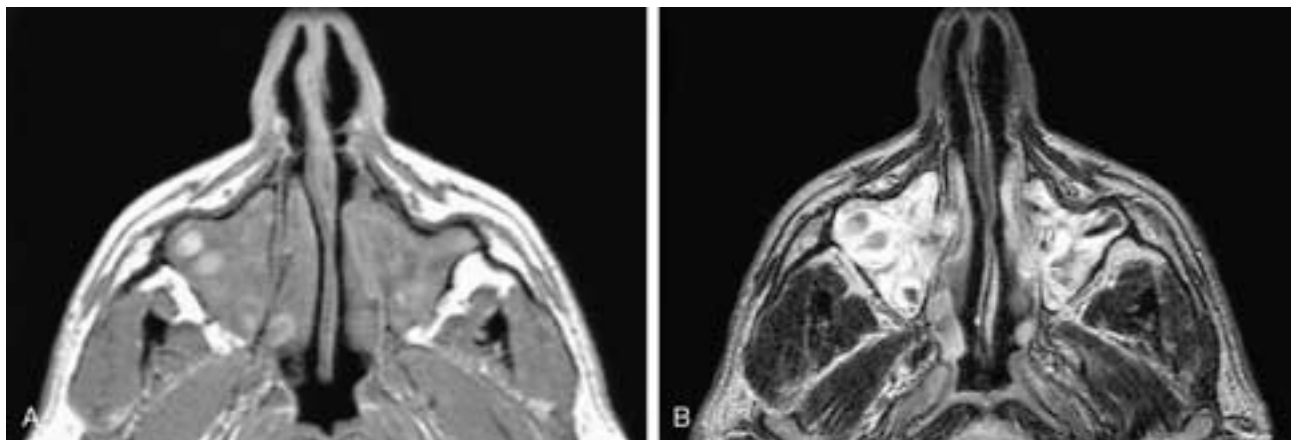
Axial T1-weighted (A) and T2-weighted (B) MR images show both maxillary sinuses filled with nonhomogeneous signal intensities. In A, the majority of the sinus content has a low to intermediate signal intensity, while in B, it has a high signal intensity. This represents heaped-up, inflamed mucosa and is the characteristic MR imaging appearance of inflammation. The areas of higher signal intensity in A and lower signal intensity in B are sites of desiccated secretions. This patient had chronic sinusitis.
